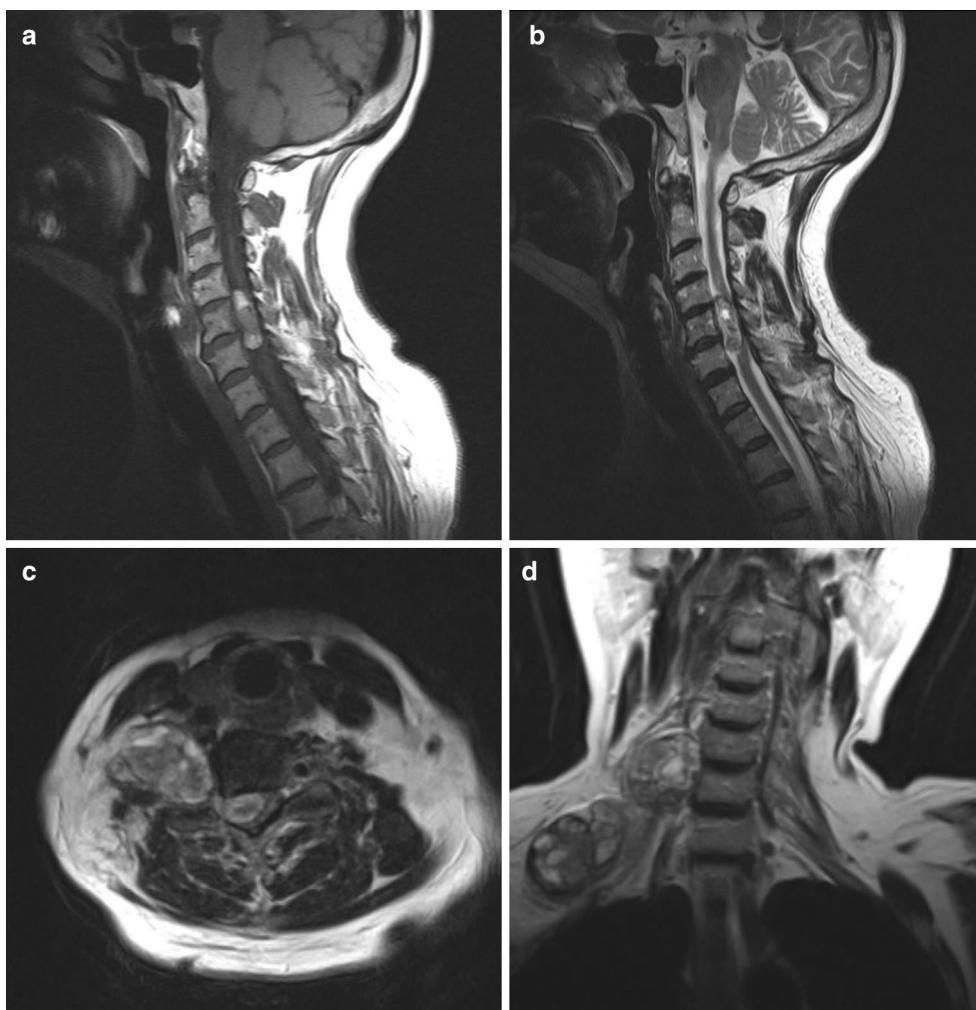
Magnetic resonance imaging (MRI) of the cervical spine. a, b T1- and T2-weighted image of sagittal section showing intraspinal canal mass lesion. c, d Axial and coronal section of C5/6 level
